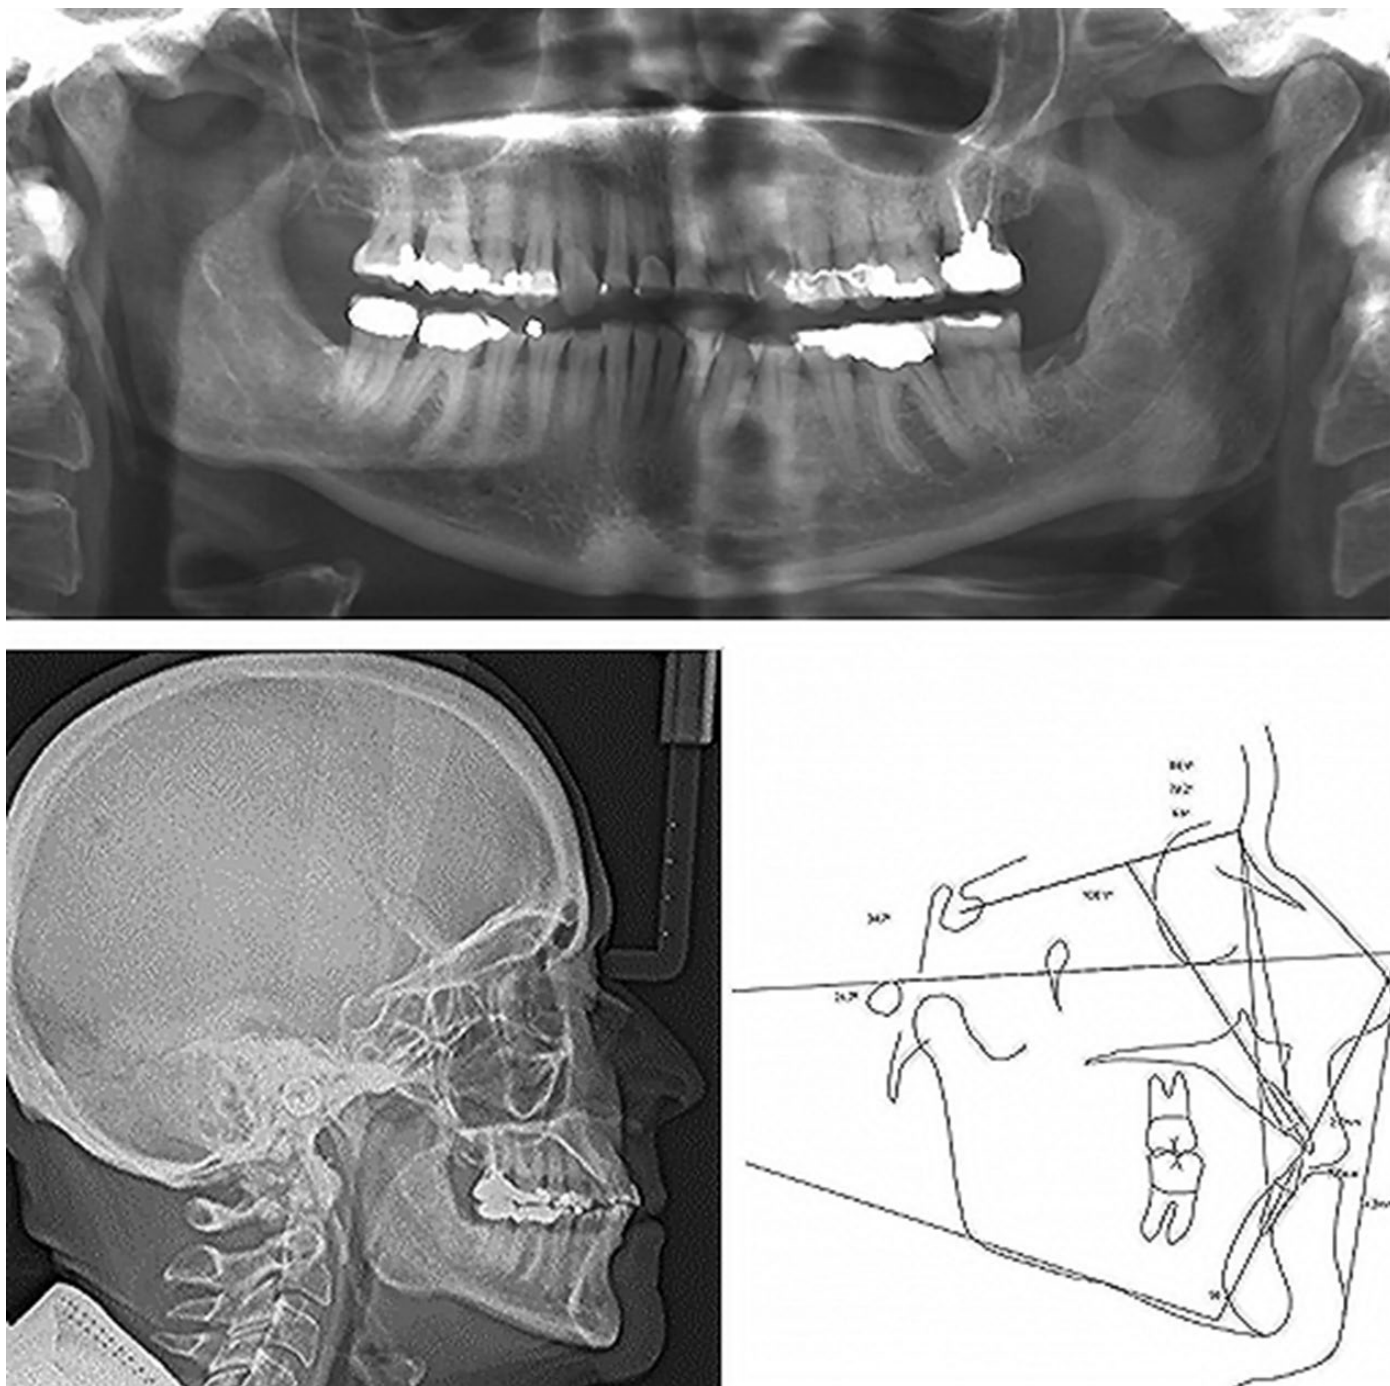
Panoramic and cephalometric radiographs and cephalometric analysis.
